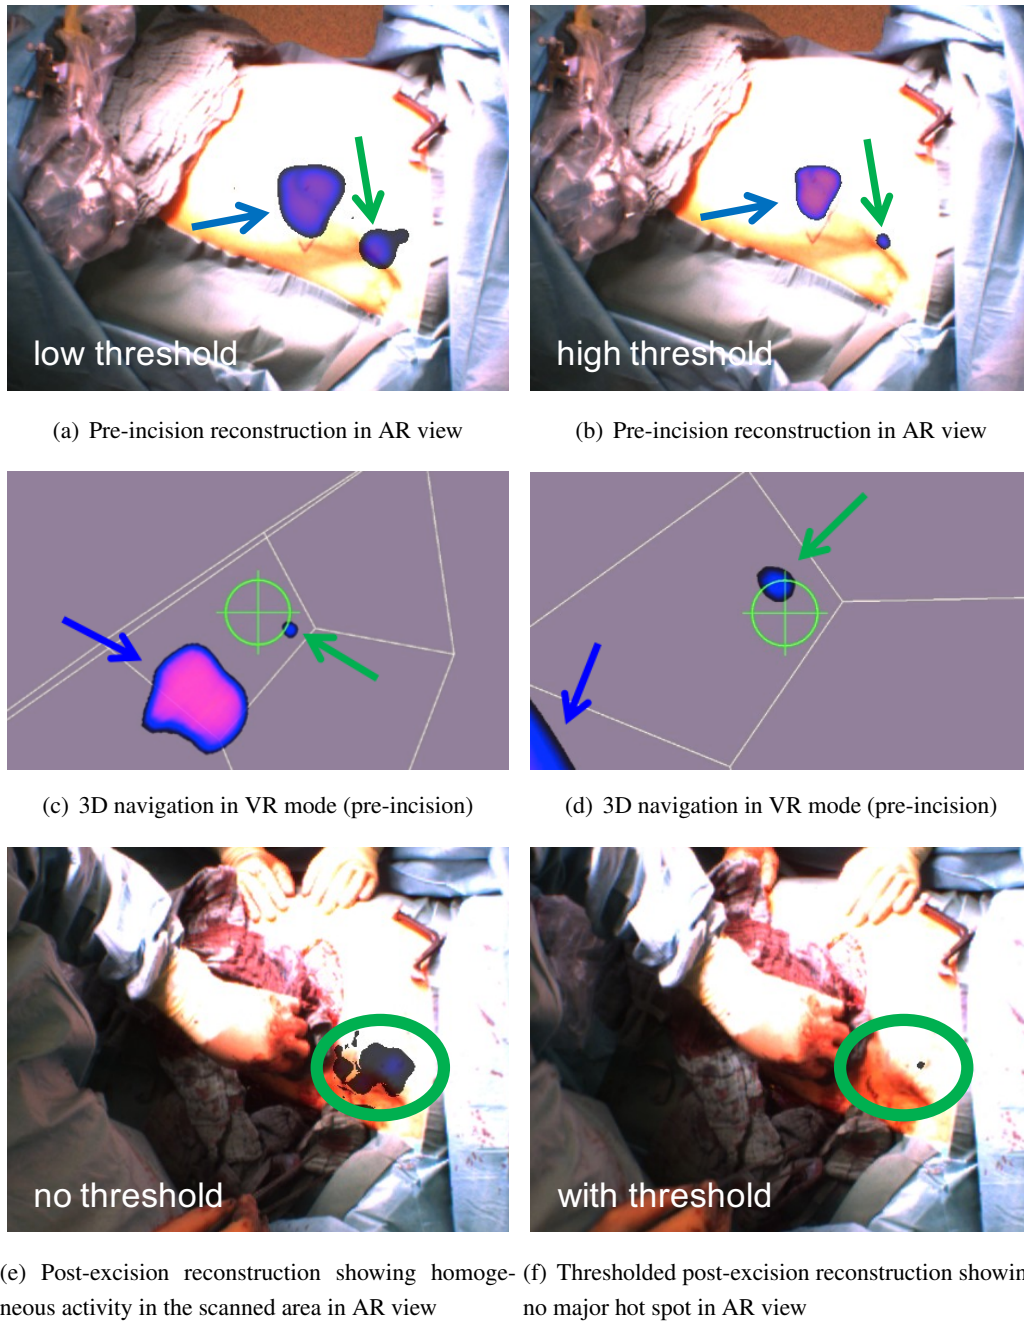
Freehand SPECT reconstructions in different surgical phases and view modes. Blue arrows: injection spot, green arrows: sentinel lymph node.
